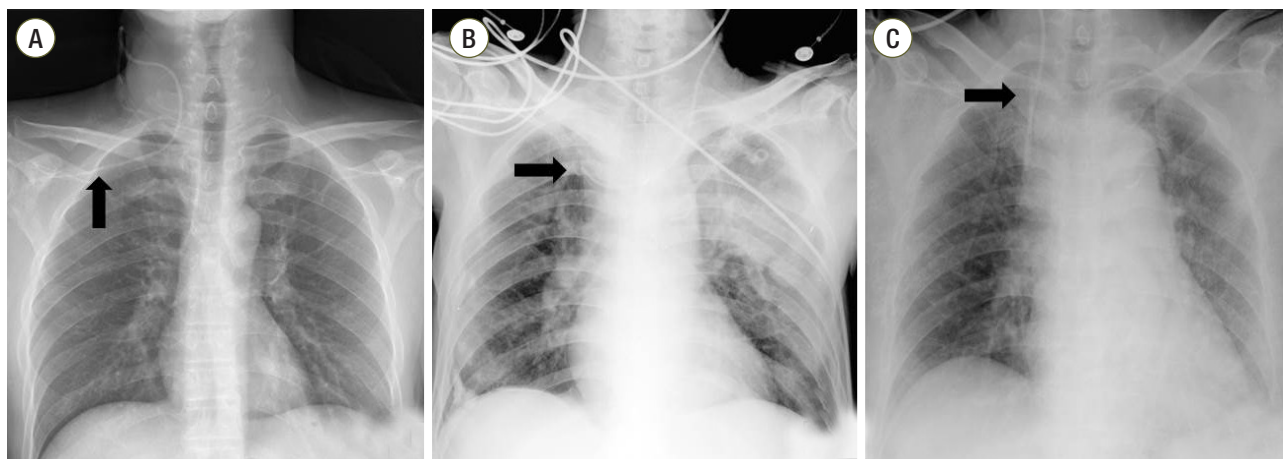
Malpositioned tips of the central venous catheter (black arrow) shown in chest X-ray anteroposterior view. (A) Ipsilateral insertion into the axillary vein via the right SCV, (B) Contralateral insertion into the right SCV, (C) Loop formation in the SVC. SCV: subclavian vein; SVC: superior vena cava.
